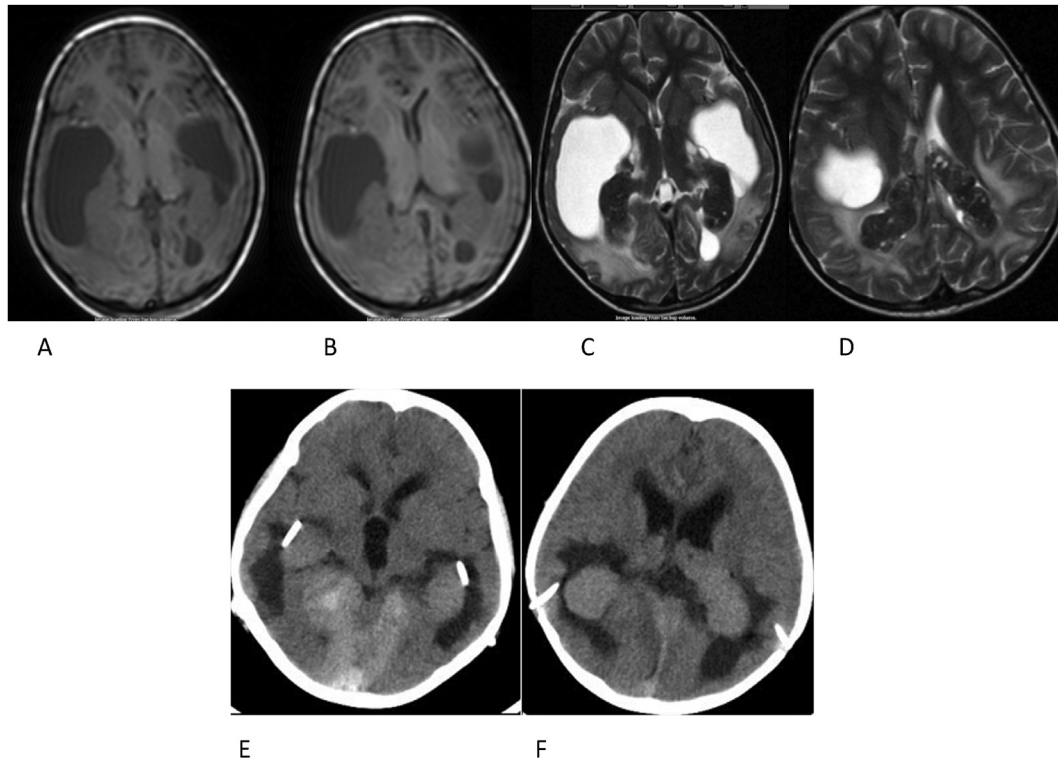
A 6-year-old boy who complaint of headache and vomit for 1 week. Head MRI revealed multiple striped or specked space-occupying lesions in the choroid plexus of bilateral ventricle, cerebral falx and bilateral tentorium of cerebellum. The lesions showed iso-intensity on T1 weighted images (T1WI) and hypointensity on T2 weighted images (T2WI). Obvious supratentorial hydrocephalous and periventricular interstitial edema were seen secondary to compression of the inter-ventricular foramen (A–D). Head CT two years later demonstrated some calcification in the lesions (E–F).
